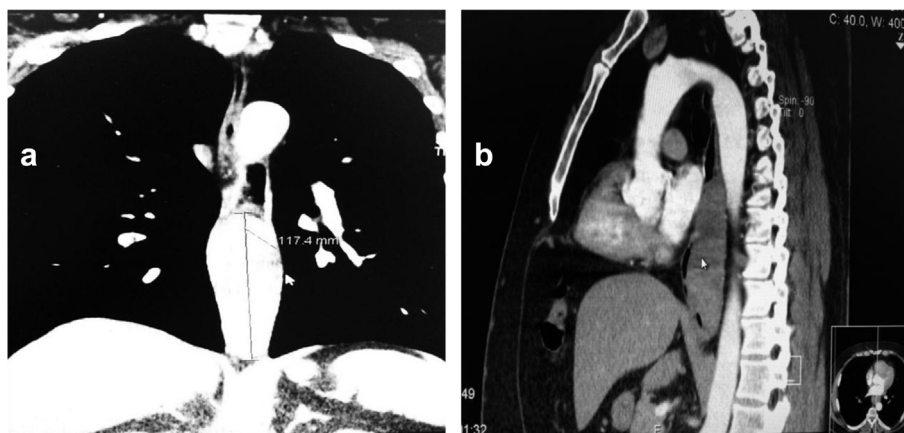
Chest CT revealed an 11 cm intramural lesion in the lower third of the esophagus, causing marked narrowing of the esophageal lumen distally and dilatation proximally. No mediastinal or hilar lymphadenopathy.
